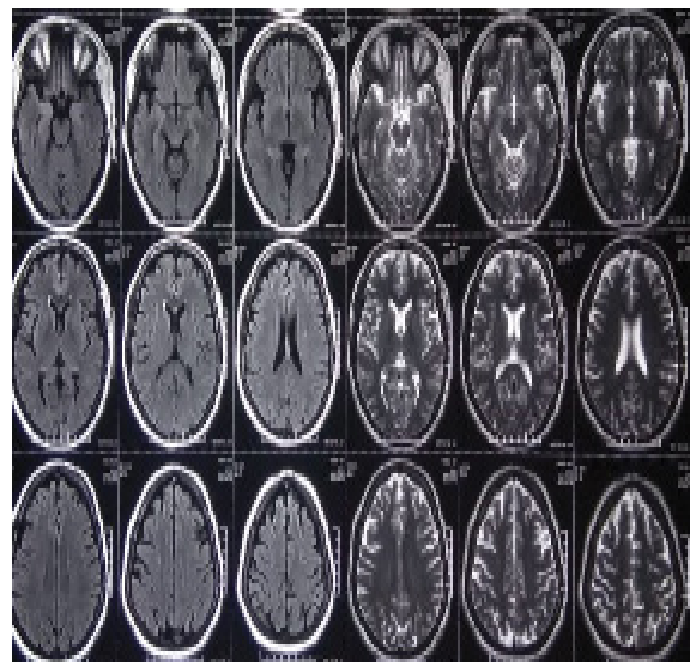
MRI Brain T2WI and FLAIR images show no abnormality.
